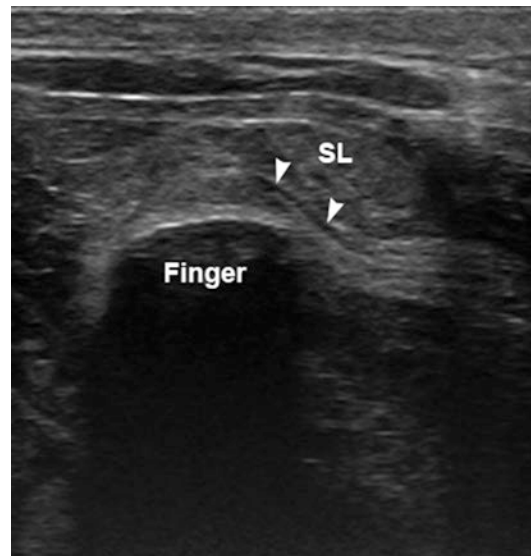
Ultrasound of the left anterior submental space with bimanual sonopalpation with gloved finger in the anterior floor of mouth (finger) compressing the tissue against the US probe. A dilated submandibular duct (*arrowheads*) can be seen alongside sublingual tissue (SL)
